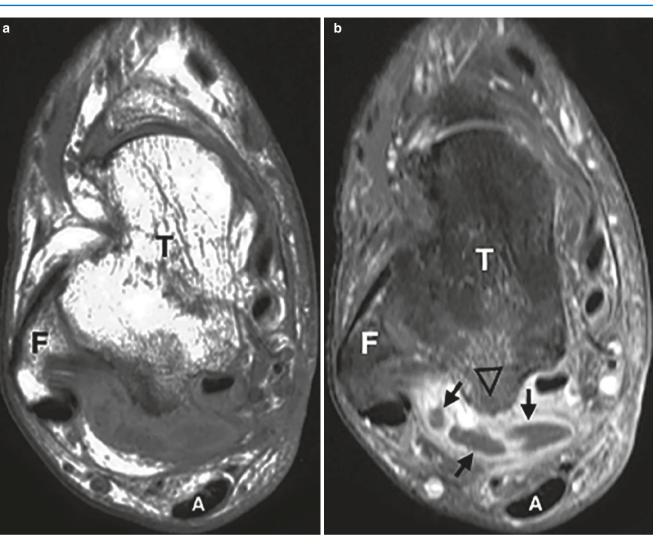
Soft Tissue Abscess on MRI. Axial images of the ankle in a diabetic patient with ankle swelling. T1-weighted image (a) shows abnormal low signal posterior to the talus. Fat suppressed T1-weighted image (b) was obtained after IV administration of gadolinium. Note the bright enhancing peripheral rim (arrows) surrounding the abscess. The
